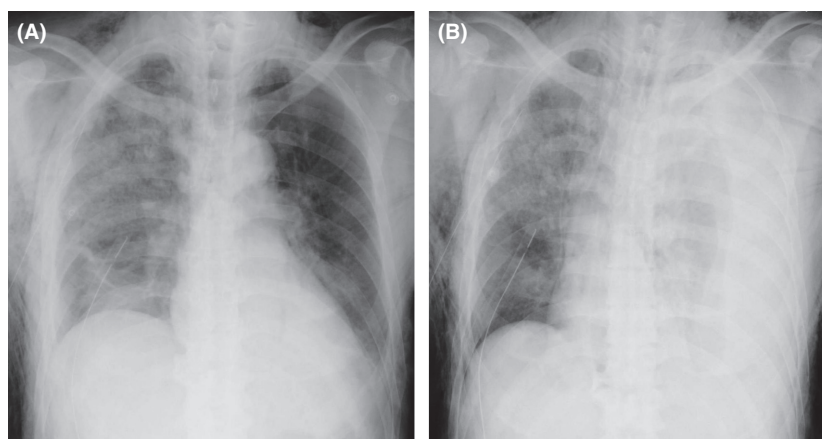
Chest X-ray film at 25 h (A) and at 35 h after injury (B). The latter shows left massive hemothorax.
